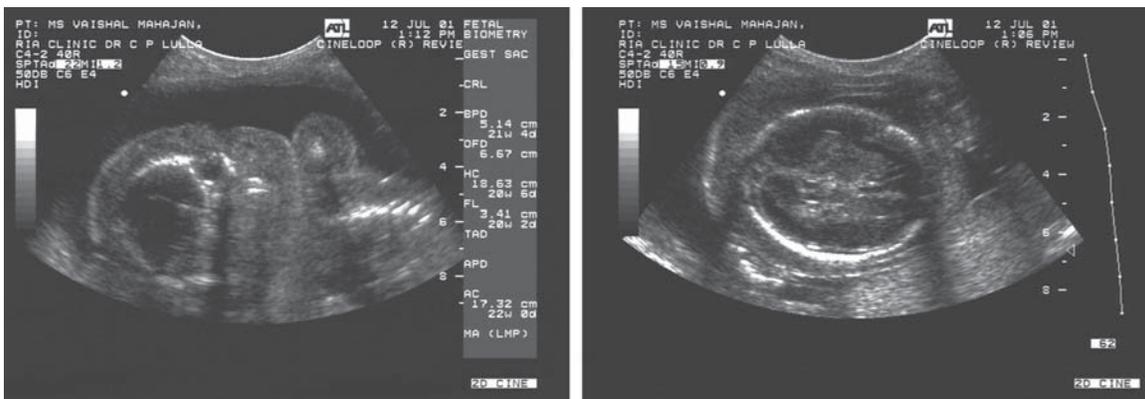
Ultrasonography showing hydrops changes in foetus
